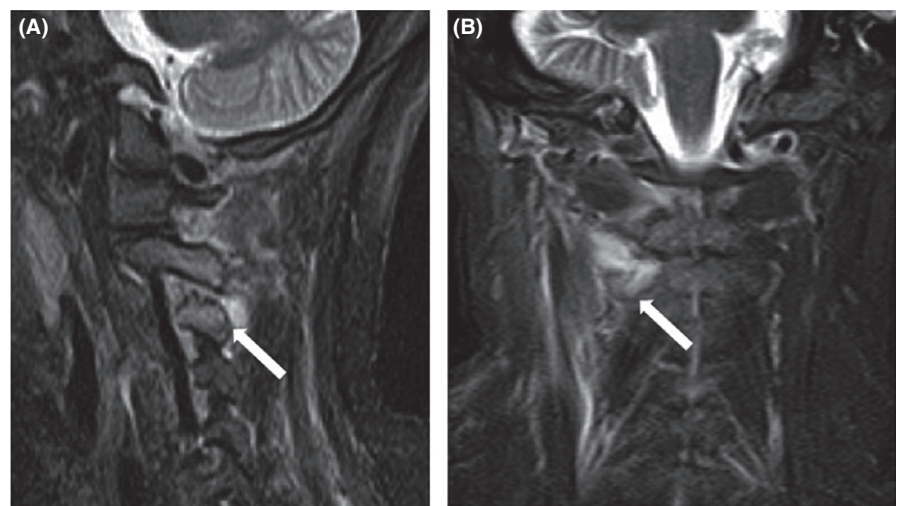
A, Sagittal T2-weighted fat saturation magnetic resonance imaging reveals erosion and a high-intensity area around the C3-C4 articular processes (white arrow). B, The coronal image reveals a high-intensity area around the right C2-C3 facet joints (white arrow)
